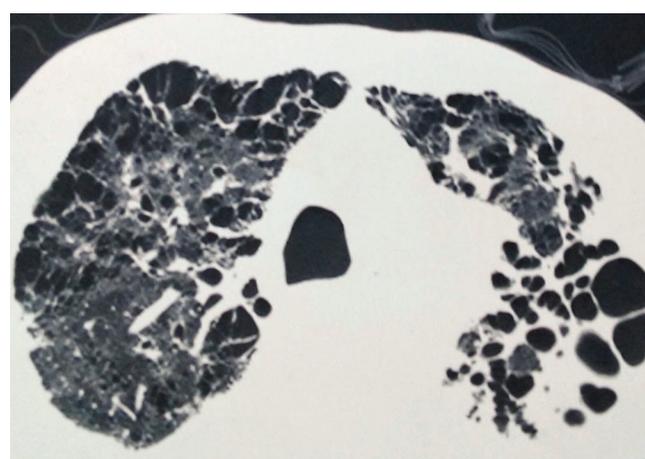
HRCT image of lung showing honeycombing and bronhiectasis
